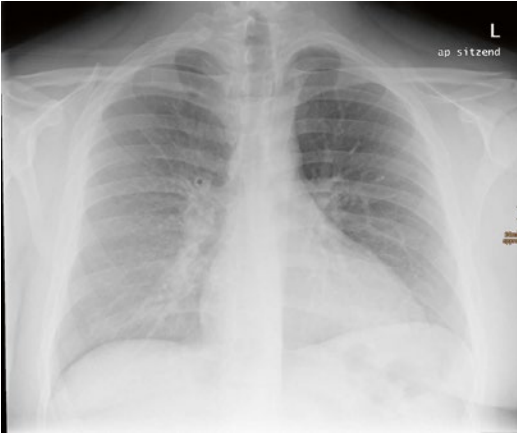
A 21-year-old man with mycoplasma pneumonia: chest radiograph showing enlarged left hilar shadow. Reticulonodular opacities in the right lower lung field
